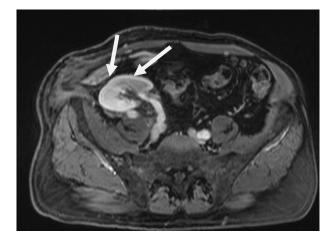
In the upper part of this image, (a) contrast-enhanced ultrasound (CEUS) clearly shows the parenchymal region with a perfusion deficit. Transplant patient with infarction in the central portion of the kidney. (b) CEUS shows a parenchymal perfusion defect. (c) MRI using contrast agent confirms the presence of a hypovascular area.
